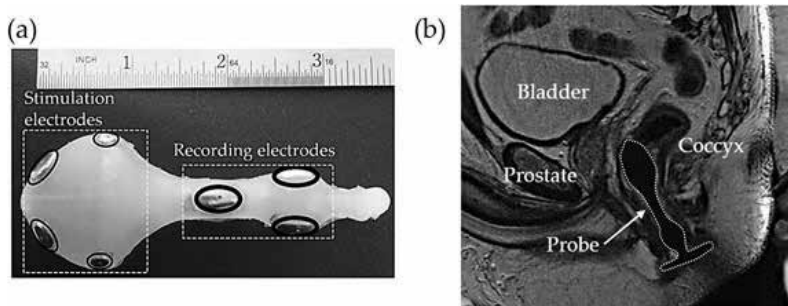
(a) The device used by Knight et al. [57] and (b) the MRI of the device *in situ*.
